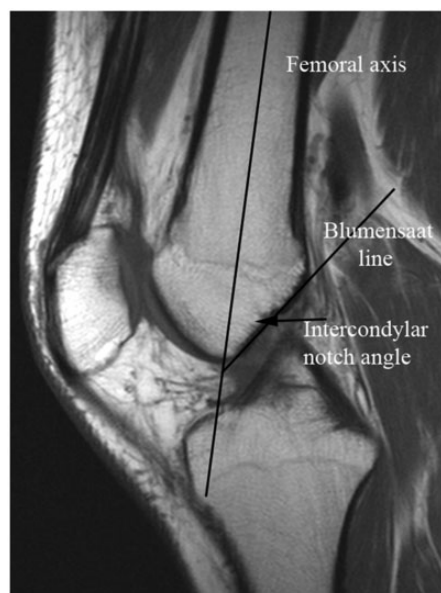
Sagittal T1-weighted image showing INA measurement (angle formed by the Blumensaat line and femoral axis). INA, intercondylar notch angle.
